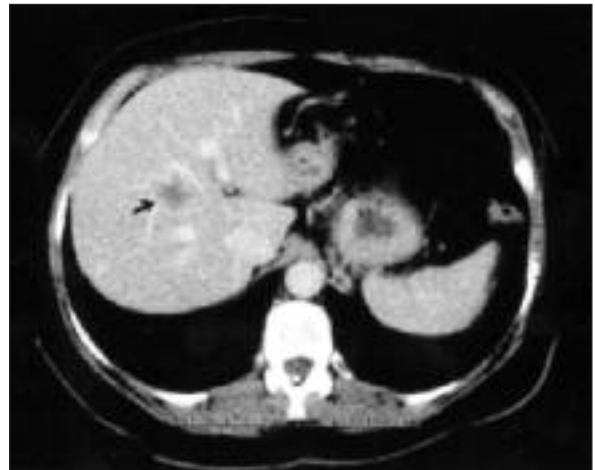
The mass was detected also with abdominal CT.
